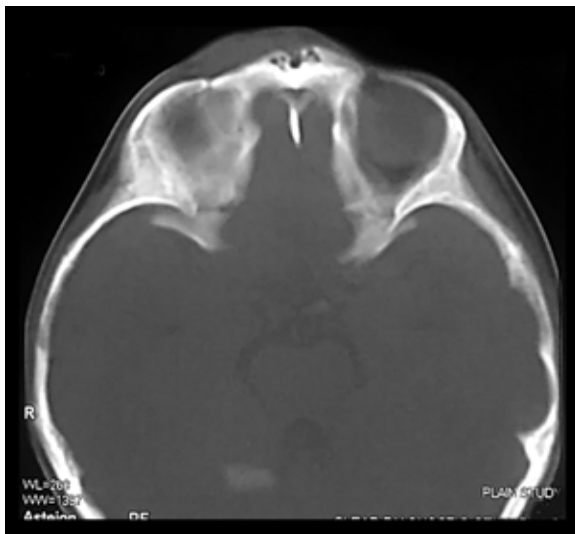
CT scan of the brain (bone window) showing a hypodense, well-defined extracranial swelling over the right supra-orbital region producing a characteristic "scalloping sign".
